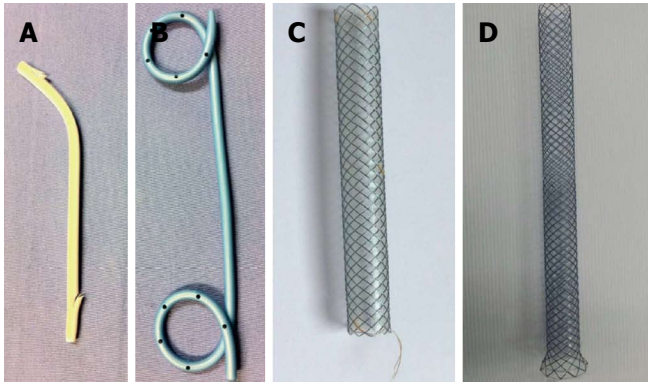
The different types of stents used in Endoscopic ultrasound guided biliary drainage. A: Plastic stent; B: Double-pigtail plastic stent; C: Fully covered, self-expandable metal stent; D: The Gio-Bor stent.
